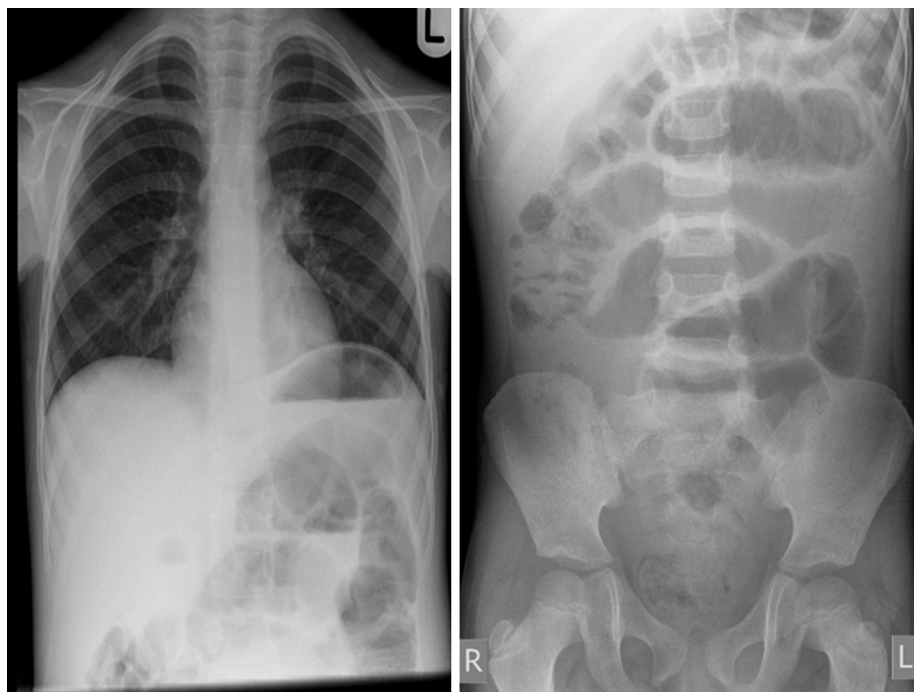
Chest and abdominal X-rays – note normal air fluid level in the stomach and soft tissue mass in right lower abdomen with bowel obstruction.
